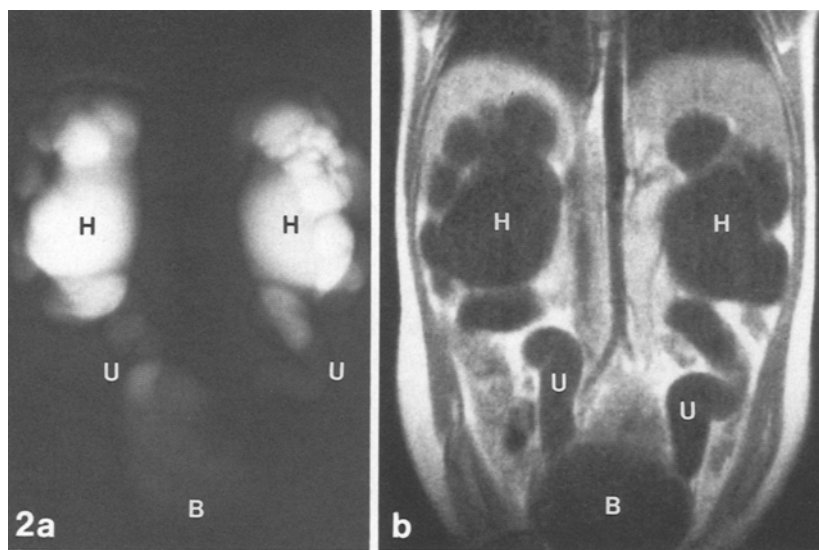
9.9-year-old neglected boy with untreated urethral valves, vesicoureteric reflux V° on both sides, and yet compensated renal insufficiency. a Coronal RARE-MR-urography, b coronal T1-weighted image: Bilateral massive hydronephrosis (H) with severe parenchymal atrophy and bilateral megaureters (U), B = bladder
